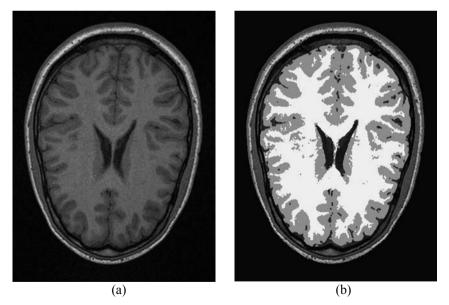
Classification result of MR brain image. (a) Slice of an 3d MR image. (b) Slice of the classification of the MR brain image. White Matter is represented in white and gray matter in gray.
